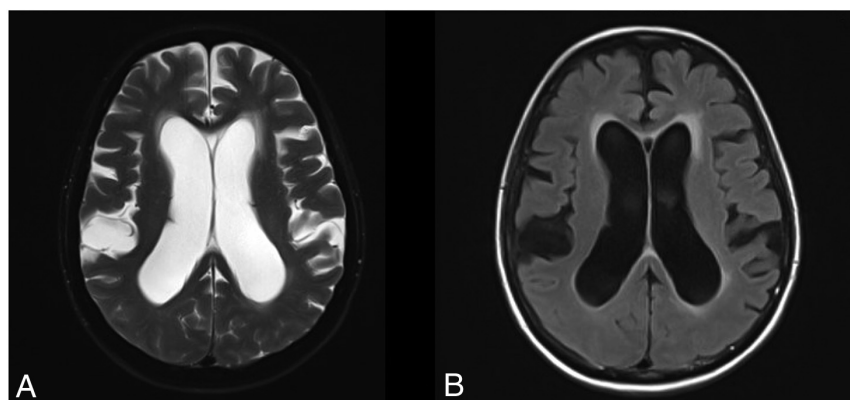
Exemplary axial images from T2-weighted (A) and FLAIR (B) sequences of an included patient.
